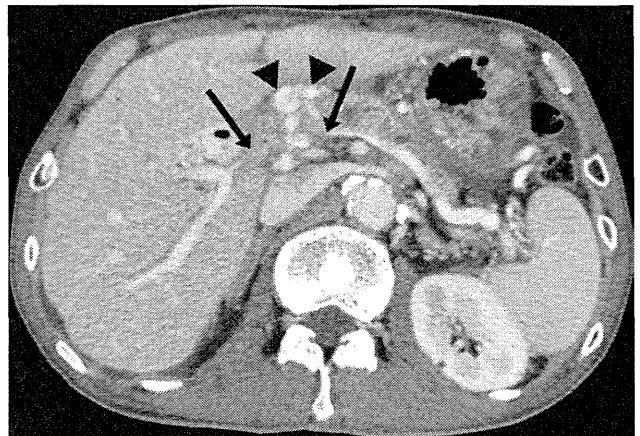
Contrast-enhanced axial CT image before treatment demonstrates portal venous occlusion extending from the right and left intrahepatic portal veins beyond the confluence of the superior mesenteric vein and the splenic vein and into each vessel (arrows). Collateral vessels are identified around the choledochojejunostomy site and porta hepatis (arrowheads).
